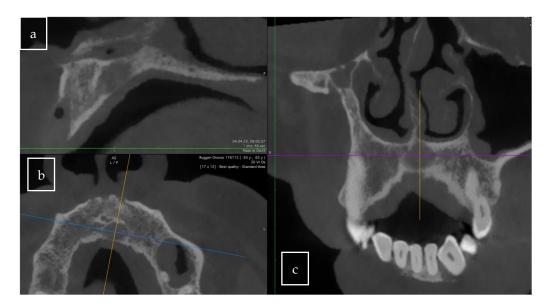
Pre-operative CBCT (a) sagittal, (b) transversal and (c) axial views revealed a radiotransparent lesion located in the palatal incisors.
